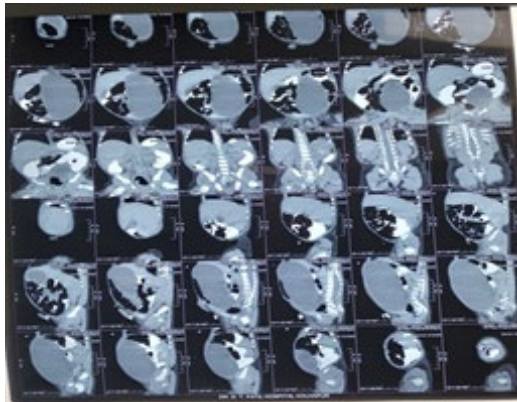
CT abdomen findings of mesenteric cyst.
